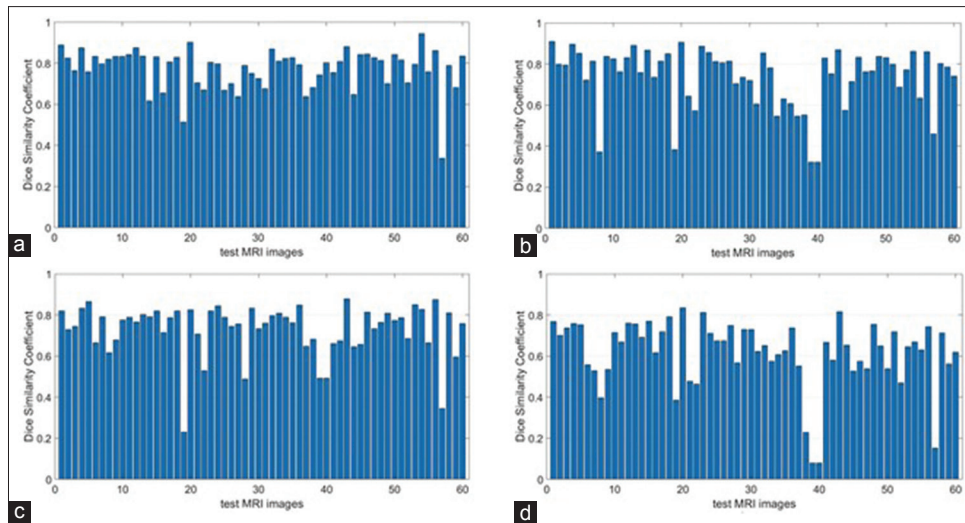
The results of Dice for single-channel magnetic resonance images in the test dataset (a) FLAIR, (b) T2-weighted, (c) T1-weighted (T1W), (d) T1W contrast-enhanced
